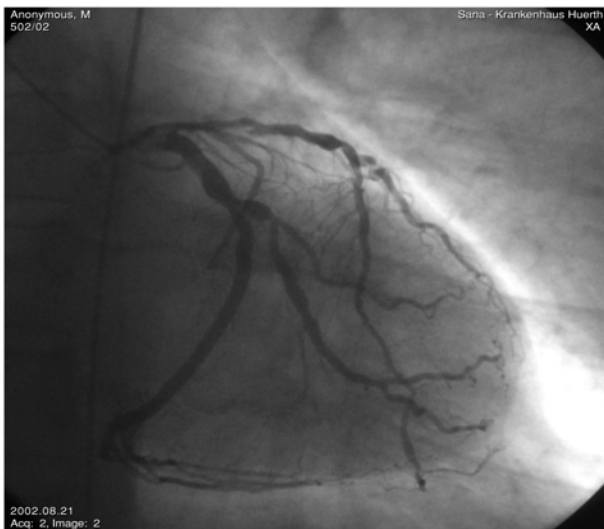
Coronary angiogram (left) and corresponding 3-dimensionally reconstructed multislice computed tomographic image of a significant left anterior descending artery stenosis (right).
